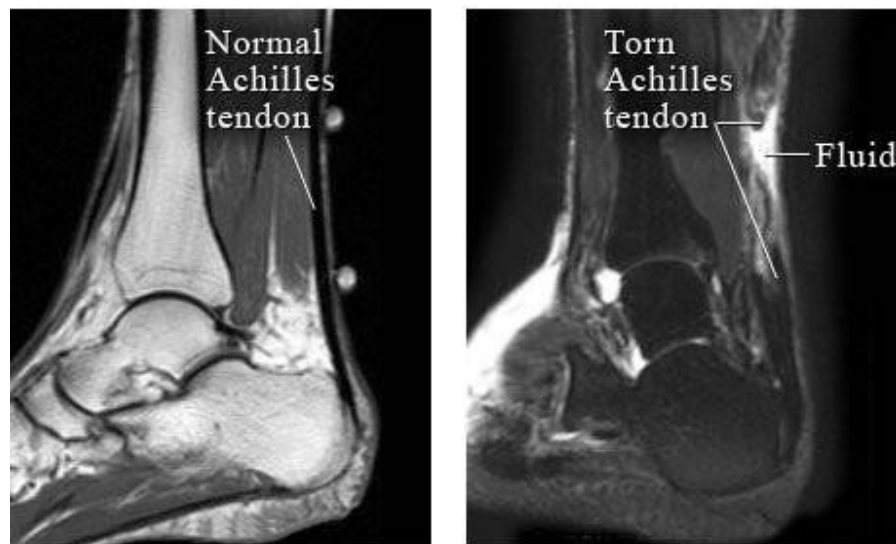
MRI: Normal and Torn Achilles tendon (25)
